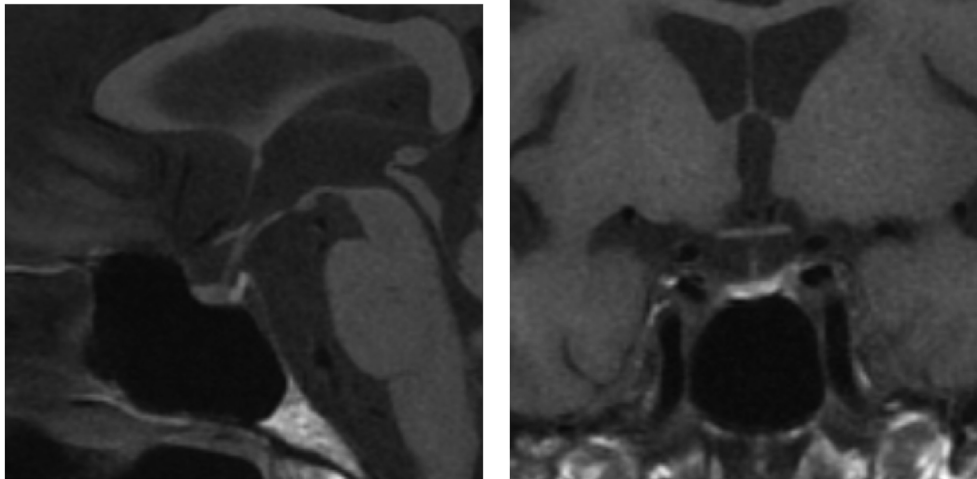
Pituitary MRI. MRI findings revealed no pituitary enlargement.
